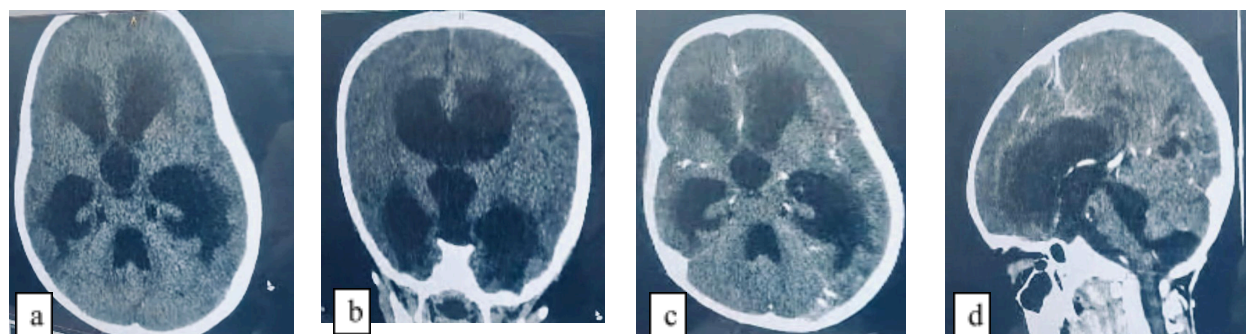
Contrast-free brain CT, axial section (1a) and coronal reconstruction (1b) showing active hydrocephalus with dilatation of all ventricular systems of the brain. Contrast enhanced axial slice (1c) and sagittal reconstruction (1d) showing raised cortical sulci and skull base, indicative of inflammation.
